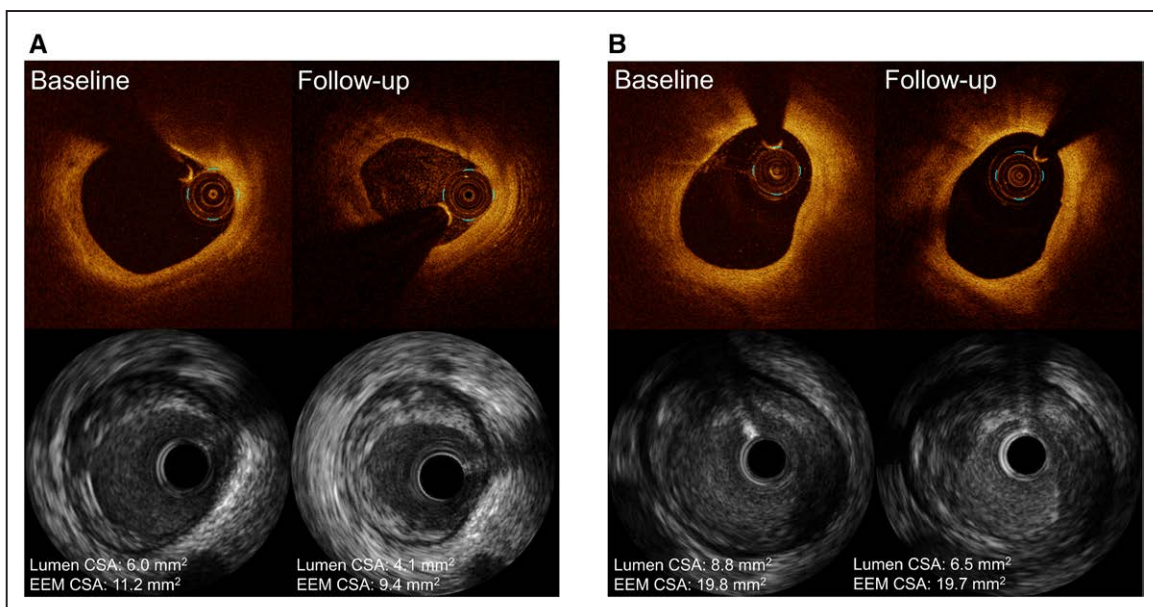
Representative cases of type III lesion progression. A, Case 1 and (B) case 2: optical coherence tomography (top) shows a lipidic plaque at baseline. At 8-month follow-up, lumen compromise was observed without a layered pattern. Corresponding intravascular ultrasound cross-sections (bottom) show progression (>0.5 mm² decreased in lumen cross-sectional area [CSA]). EEM indicates external elastic membrane.
